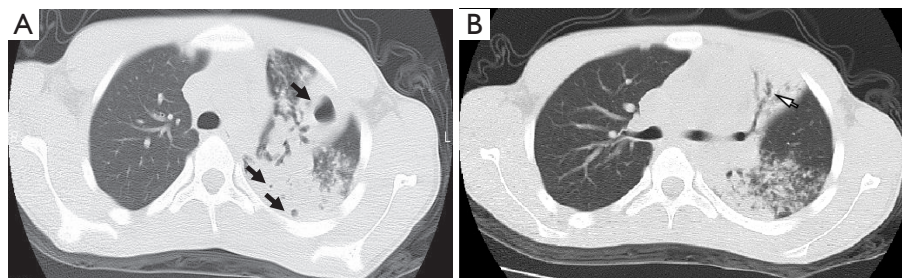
CT of a case of drug-resistant (isoniazid, moxifloxacin) pulmonary tuberculosis (male, 13 years old). (A) Multiple nodules, patches, and flaky consolidation shadows are seen in the apicoposterior segments of the left upper lobe and the dorsal segment of the lower left lobe with uneven density and unclear edges; and multiple wall-less cavities (black arrows) are seen inside the consolidation shadow; (B) the bronchus of the left upper lung is slightly narrowed, and the distal end is irregularly dilated (white arrow). CT, computed tomography.
